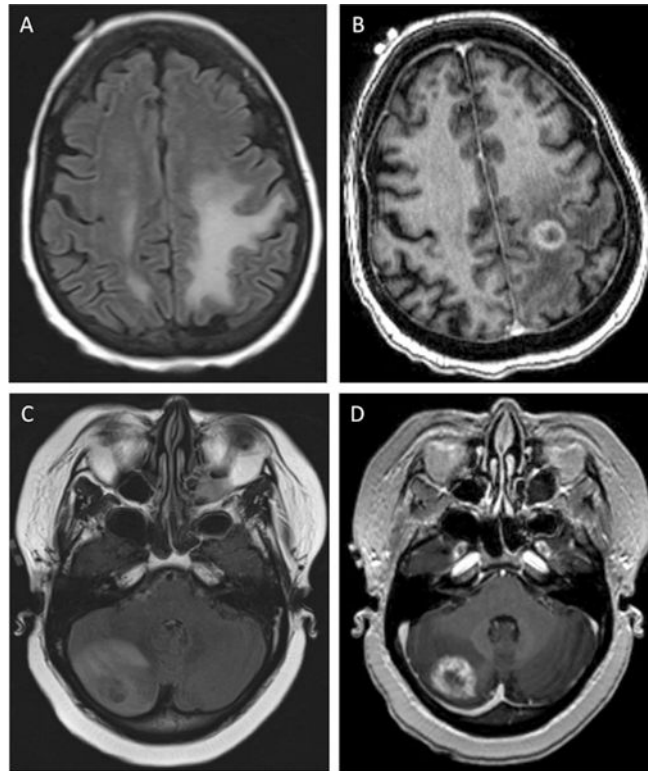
Progression and treatment effect of brain metastases on magnetic resonance imaging. Top: T2 Fluid-attenuated inversion recovery (FLAIR) (A) and T1 post-contrast (B) images for a patient with treatment effect of a left prefrontal metastasis from non-small cell lung cancer. Bottom: T2 FLAIR (C) and T1 postcontrast (D) images for a patient with true progression of a right cerebellar metastasis (breast primary) after stereotactic radiotherapy. Both cases were confirmed by surgical pathology.
